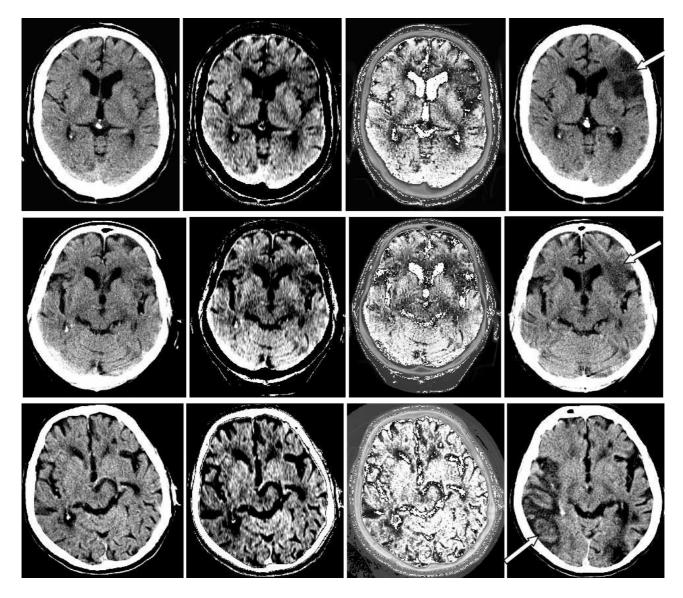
Three selected examples (in successive rows) of improved acute stroke detection: early stage of infarction in 40/30 window (left column), histogram-based window adjustment (middle-left), wavelet-based image processing (middle right), and follow-up CT scans used for confirmation (right column with infarctions indicated with arrows).
